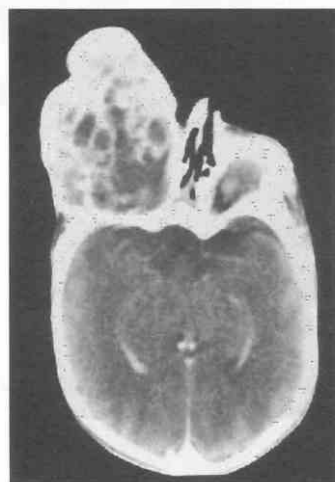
Axial contrast-enhanced CT scan shows calcified teratoma with areas of enhancement.
